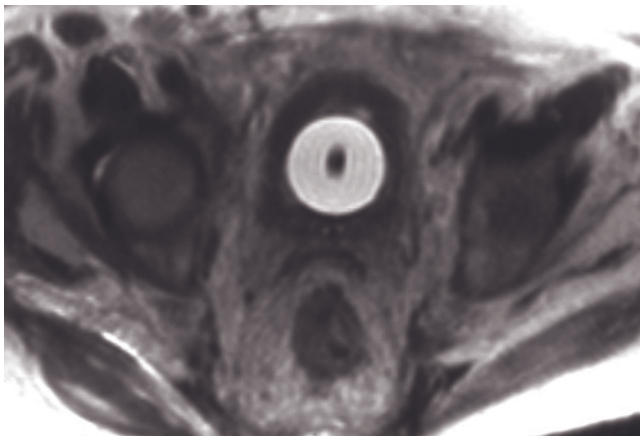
Radiation changes. Sagittal (a) and transverse (b) T2-weighted single-shot echo-train spin-echo and sagittal (c) and transverse (d) T1-weighted gadolinium-enhanced fat-suppressed SGE images in a patient with primary cervical cancer who underwent radiation therapy. The bladder wall is diffusely thickened (a-d), and it enhances intensely and homogeneously after gadolinium administration (c, d). Note the dependently layering low-signal material in the bladder on the T2-weighted images, compatible with proteinaceous material and a clinical history of hematuria. Reticular strands in the perivesical fat and colorectal wall also enhance intensely because of inflammatory changes. T1-weighted fat-suppressed SGE (e) and T2-weighted fat-suppressed spin-echo (f) images
